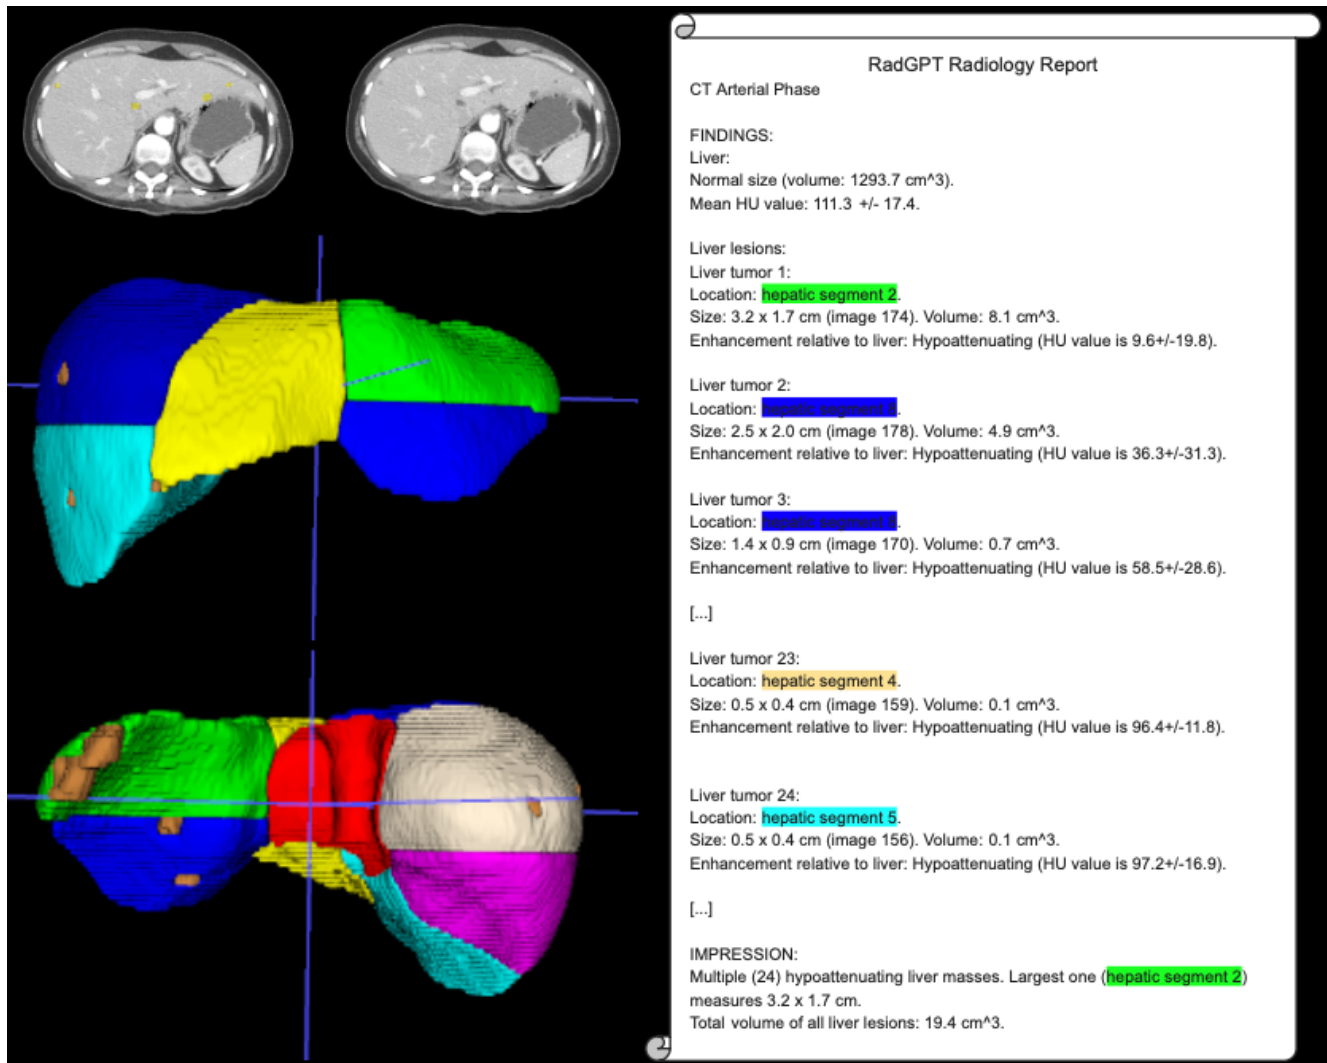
CT scan with 24 liver tumors (brown), showing how we segment the liver into eight sub-segments for tumor localization. Notably, unlike our report, most human-made reports would not describe 24 tumors in detail, due to the time required for this task. Liver sub-segments are functionally independent, and can be surgically removed without influencing nearby segments. Thus, localizing tumors into these segments is important for tracking tumors and for surgical planning.
